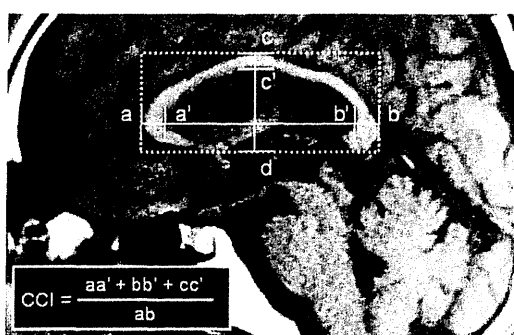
Determination of the corpus callosum index (CCI) using a midsagittal slice on a T1-weighted MR image (HDLS patient 2 in Table 1, 41-year-old man).
